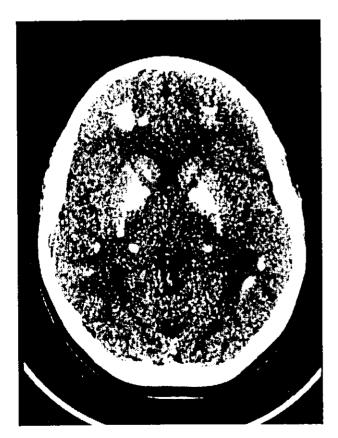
Brain CT findings. Brain CT showed multiple calcification in the dentate nucleus, thalamus, putamen, globus pallidus, caudate and subcortical white matter.
